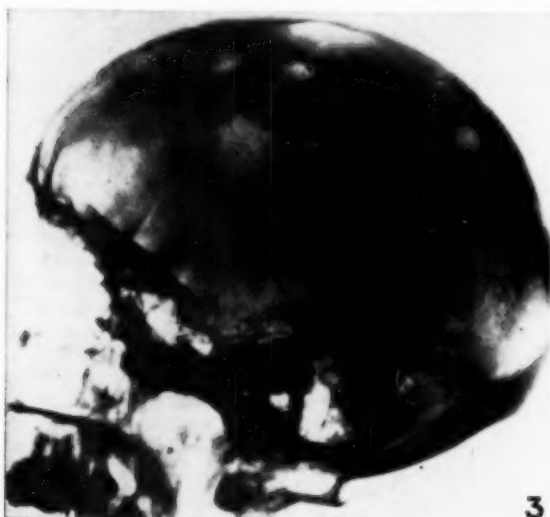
X-ray of skull on 20 September 1954.
